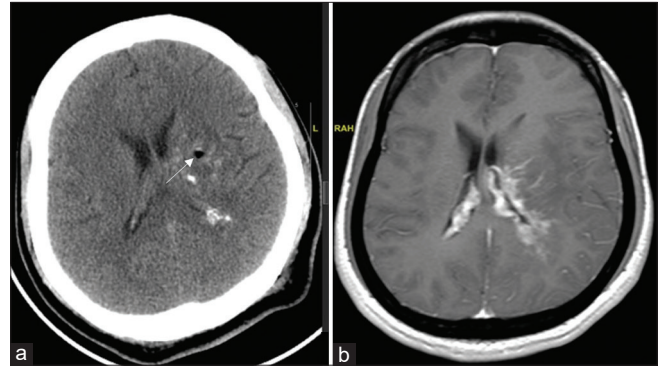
(a) Post procedure plain computed tomography showing intralesional calcification as an indirect evidence at corresponding cuts with a white arrow indicating the biopsy site. (b) In an index case of left thalamocapsular glioma preoperative contrast magnetic resonance imaging sequence.
